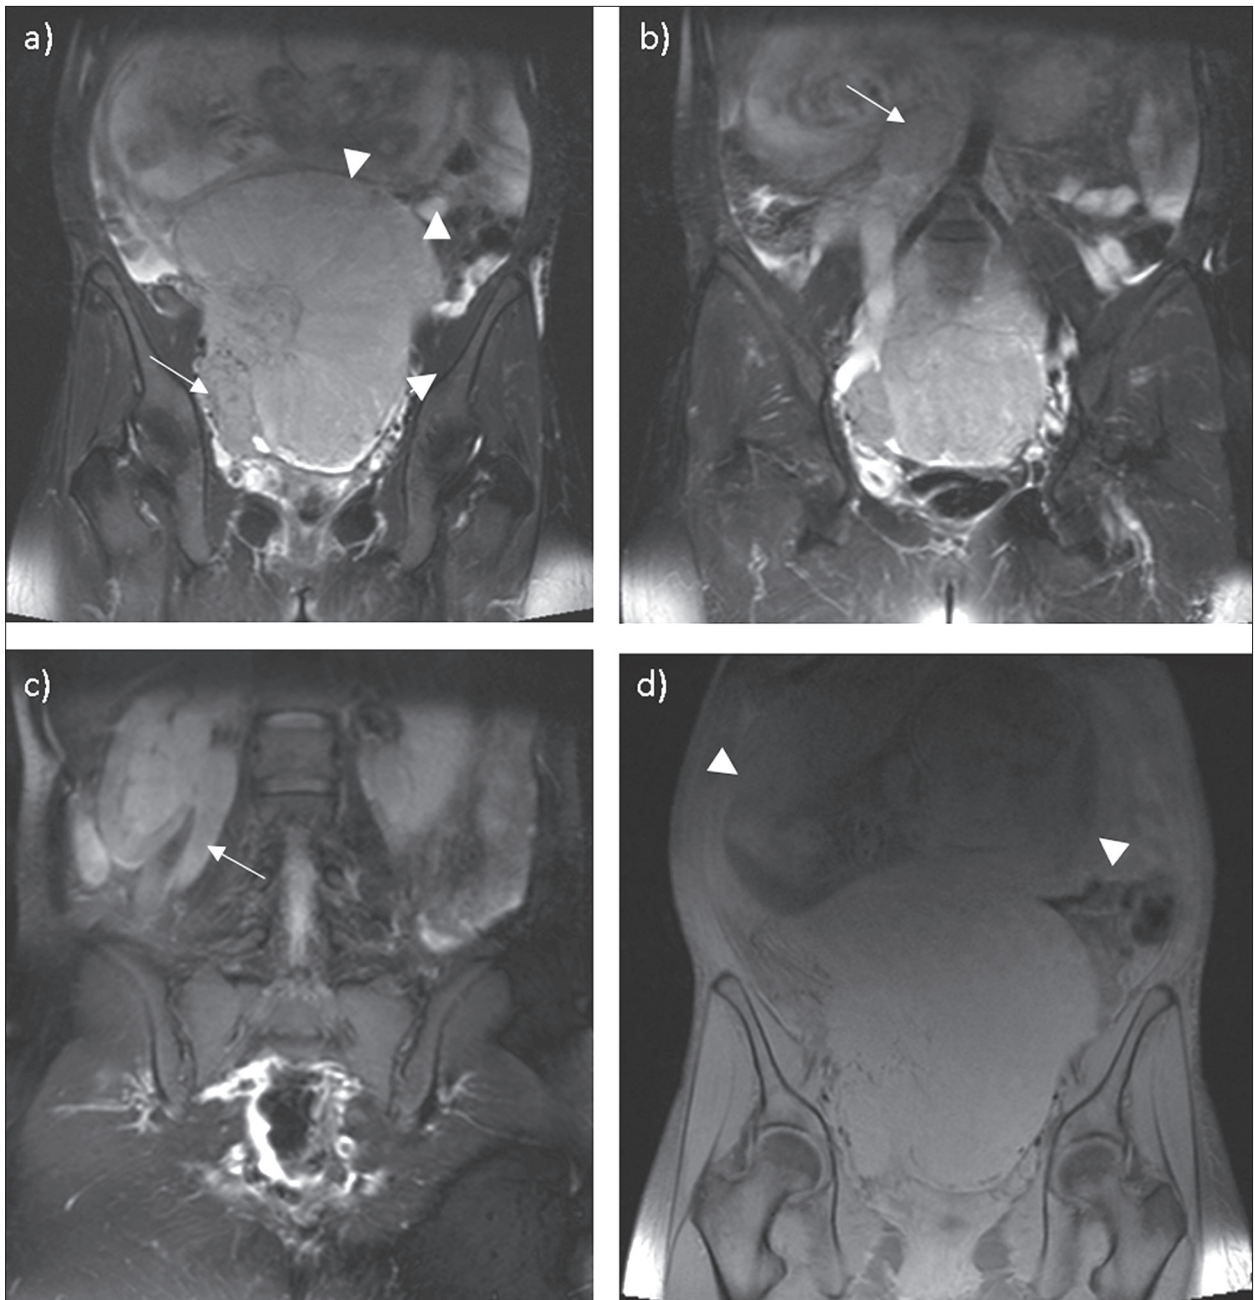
Pelvic MRI; coronal reconstructed T2-weighted images show: a) a large intermediate signal solid mass with prominent fibrovascular septa, occupied pelvic cavity with upward extension into abdominal cavity (arrowhead); in the caudal part of the mass another lobulated mass corresponding to a conglomerate of lymph nodes is shown (arrow); b) para-aortic lymph node mass (arrow); c) mass effect on adjacent structures with consequent hydronephrosis; the diameter of the ureter measured up to 13 mm (arrow); d) coronal fat-saturated T1-weighted image shows the displacing of fetus cranially (arrowhead)
